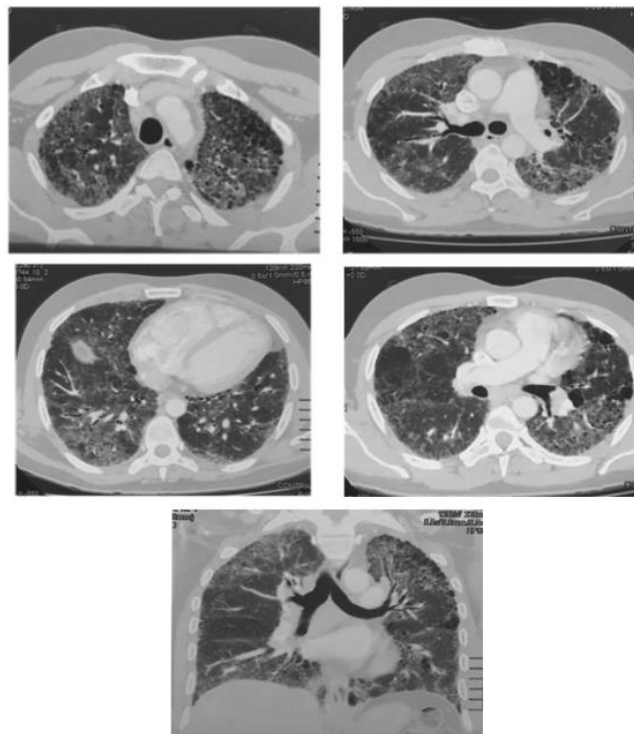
High-resolution CT scan (lung window) showed thickened lines, hazy areas, bilateral small cysts, traction bronchiectasis, and ground-glass attenuation
